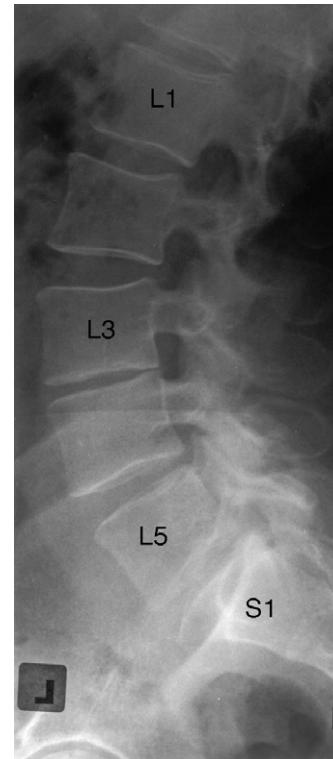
Lumbosacral spine erect posture lateral plain X-ray image. Note (i) the L3–4 intervertebral disc space height is grossly narrowed due to surgery at this level, (ii) the minor narrowing of the intervertebral disc space height at L4–5 level (due to posterior disc bulging seen on the pre-surgery CT scan), and (iii) there is essentially no osteophytic lipping on any vertebral bodies to suggest that the patient has a 'degenerative lumbo-sacral spine'.
